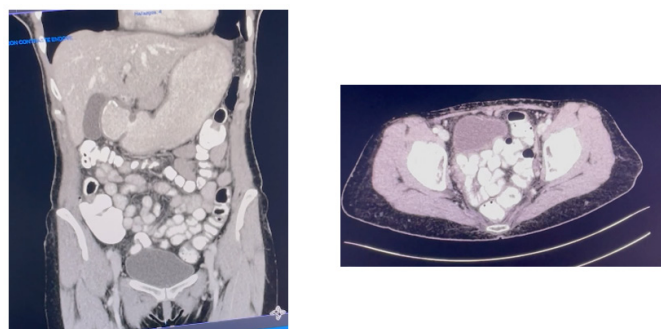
Computed tomography scan showing redundant colon "dolichocolon"
